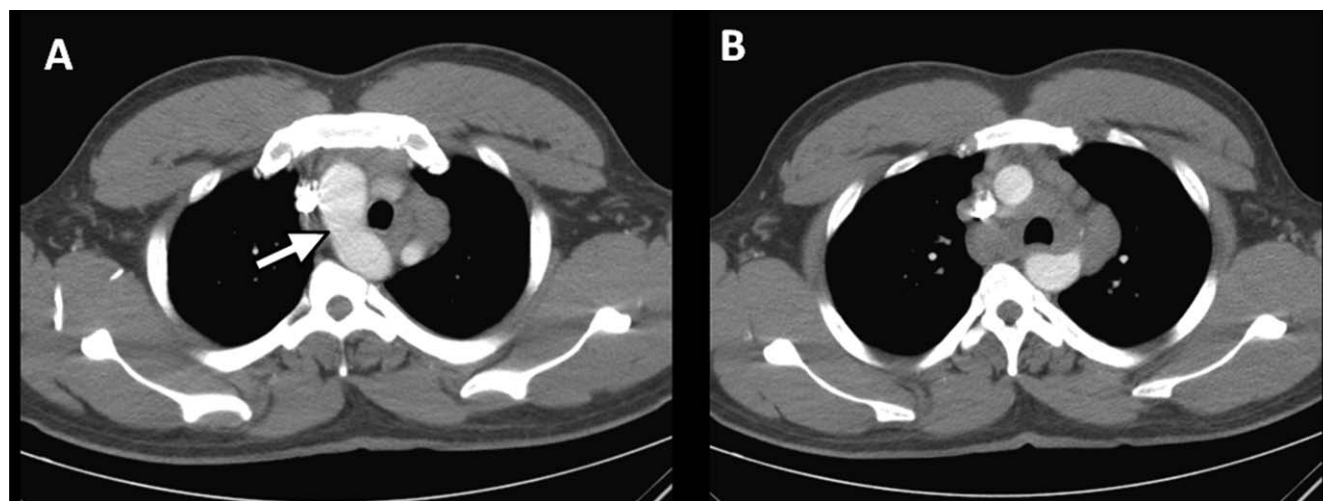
Computed tomography scan of the chest showing right-sided aortic arch (A) and extensive mediastinal lymphadenopathy (B).
